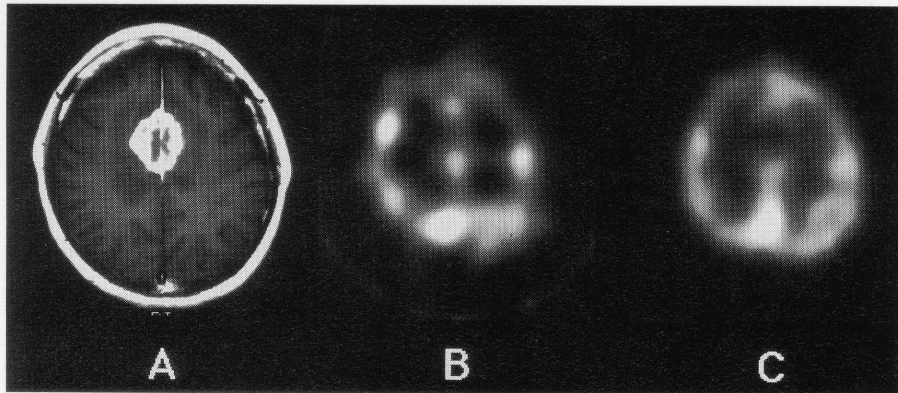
MRI (A), "super-early" SPECT (B), and "early" SPECT (C) of a 44-year-old woman with a metastatic brain tumor from lung cancer. IMP uptake in the tumor region, which was decreased in the "early" image, was as high as that in the surrounding brain tissue in the "super-early" image. The early/super-early count ratio of the tumor in this case was 1.43 and blood flow value obtained by the microsphere model using the "super-early" SPECT image was 33.0 ml/100 g/min.
